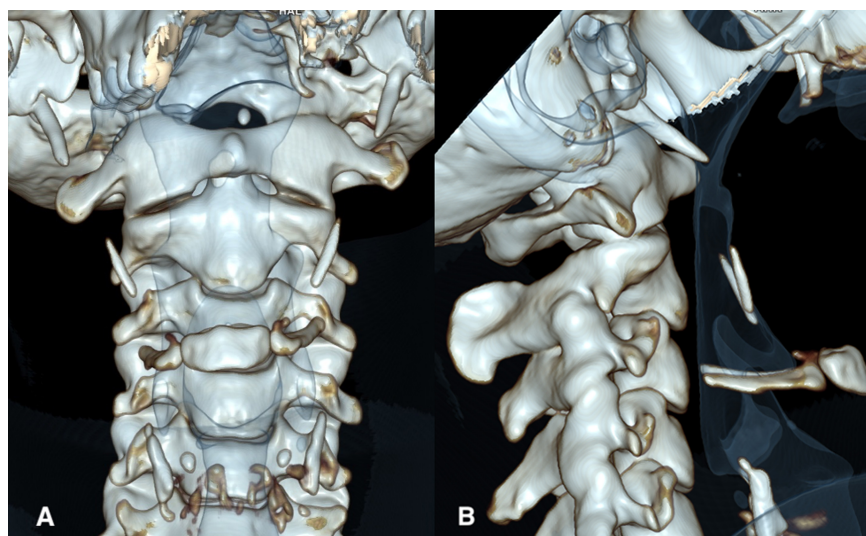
Frontal (A) and lateral (B) views of a 3-dimensional volume rendering of computed tomography images of the neck show bilateral symmetric linear calcifications between the styloid process and the hyoid bone. Note the angle of the calcifications on the lateral view, which is different from the angle of the styloid process.
